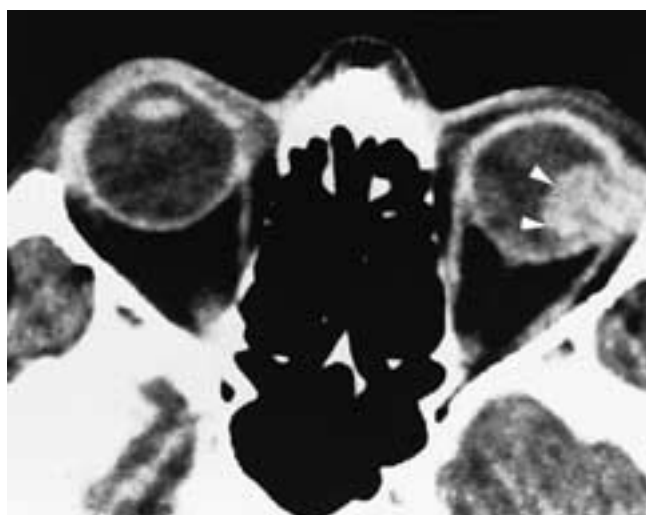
Malignant melanoma of the choroid. Axial CT scan shows a mushroom-shaped mass with increased density in the temporal quadrant of the left globe (*arrowheads*). (From Mafee MF et al. Malignant uveal melanoma and similar lesions studied by CT. *Radiology* 1985;156:403–408.)
